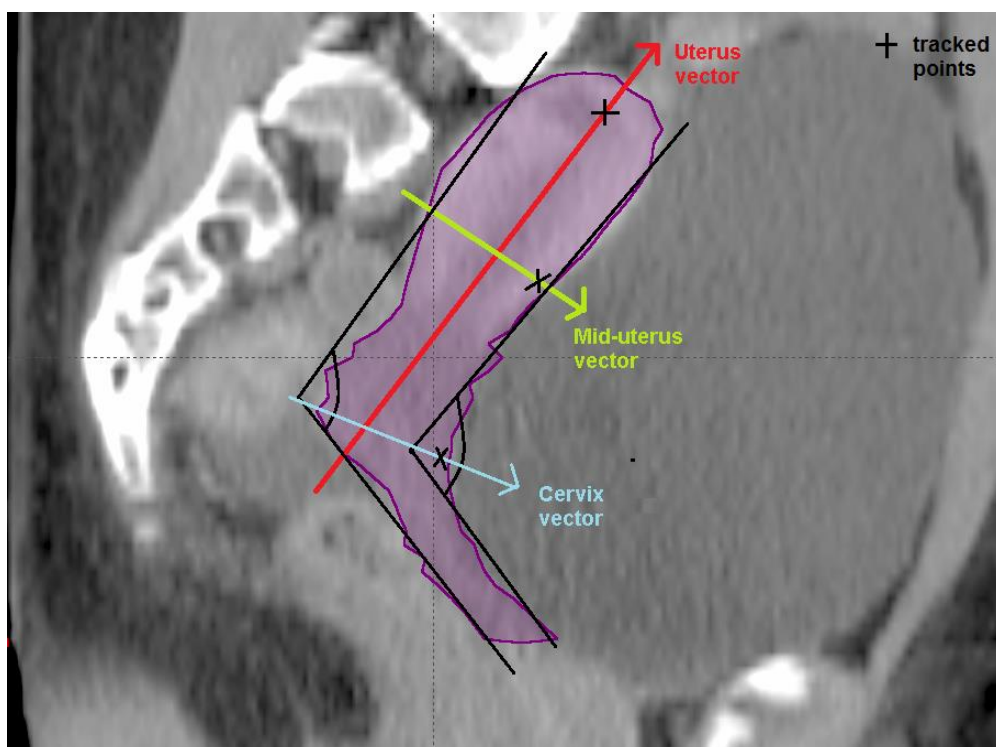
Central sagittal CT showing CTV vectors and dose points; uterine vector (red), mid-uterus vector (yellow) and cervix vector (blue) with the three dose points marked as Xs.
